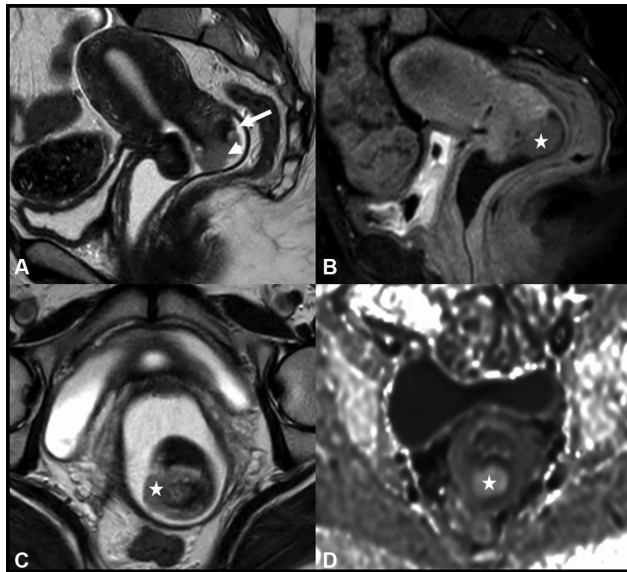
A young 34-year-old lady with a history of postcoital pervaginal bleeding. Magnetic resonance imaging shows early-stage cervical lesion, pathologically proven as squamous cell carcinoma. (A) Small field of view sagittal T2-weighted image shows a polypoid exophytic lesion (marked by arrowhead) arising from the posterior lip of the cervix. Arrow shows superior delineation of the posterior vaginal fornical space, due to intravaginal instillation of lignocaine, distending the vaginal space. In this case, the posterior fornix and vaginal wall are clearly seen as uninvolved by the disease. (B) Postcontrast imaging shows differential poor enhancement of the lesion (marked by *). (C) Small field of view axial T2-weighted image shows lignocaine jelly surrounding the cervical lips and vaginal wall, also helping in ruling out lateral parametrial invasion. (D) Diffusion weighted imaging shows restricted diffusion seen as a high signal intensity (marked by *).
